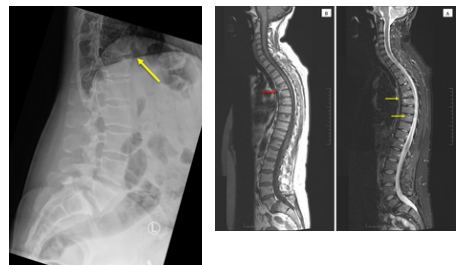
Lumbar Spine X-Ray (September 2023): There is disc space narrowing at the L5-S1 level. There is disc space narrowing at the T10-11 and T11-12 levels. New bone formation between T11-12 (yellow arrow).
